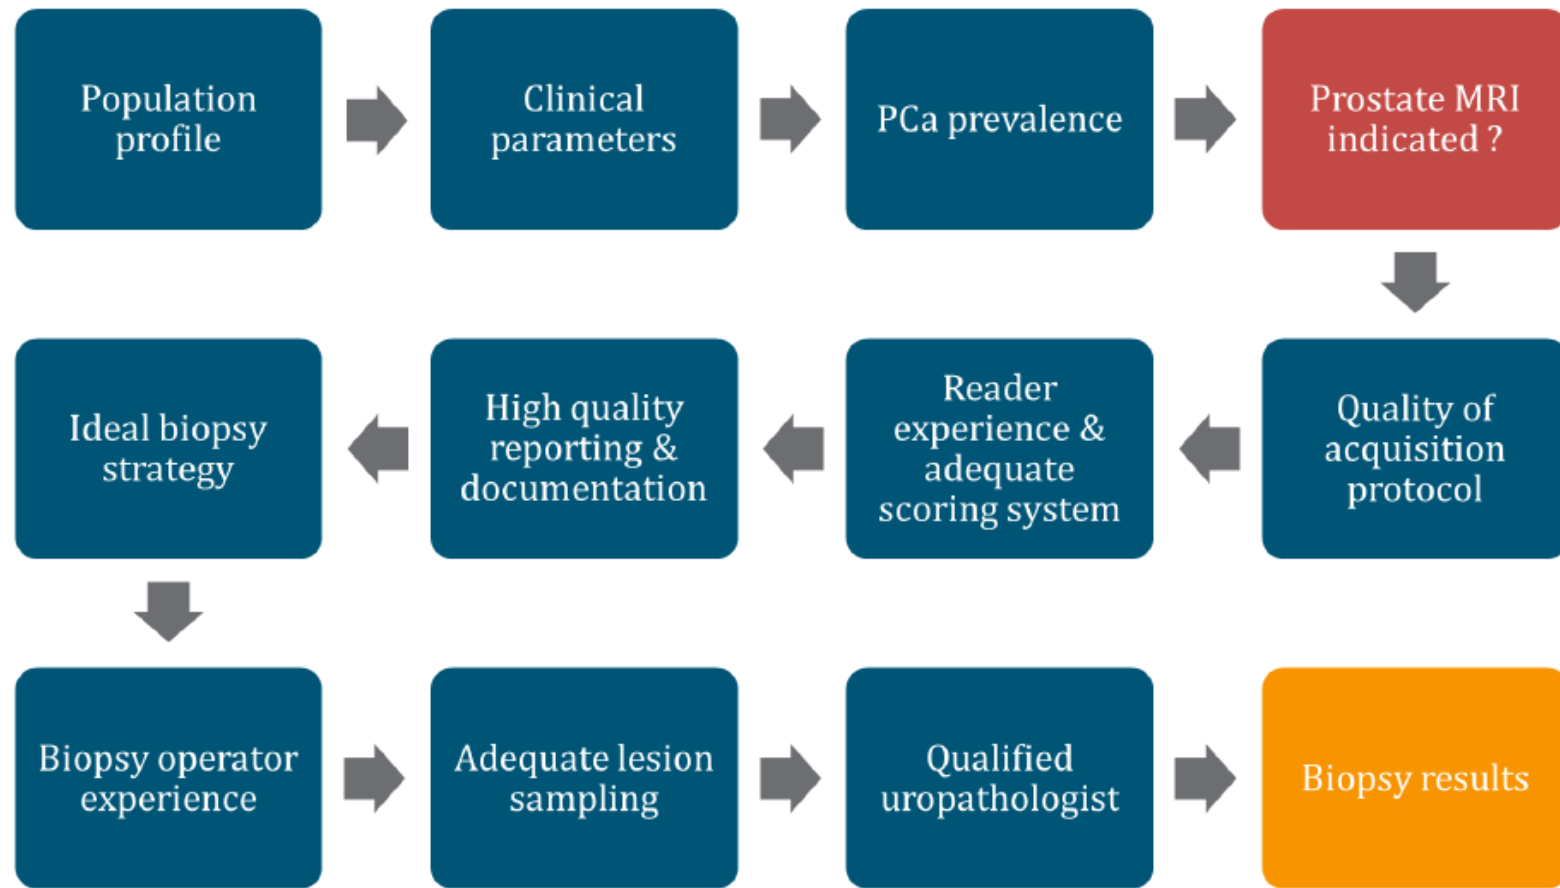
Factors that can influence the biopsy outcome of an MRI-guided diagnostic pathway.
